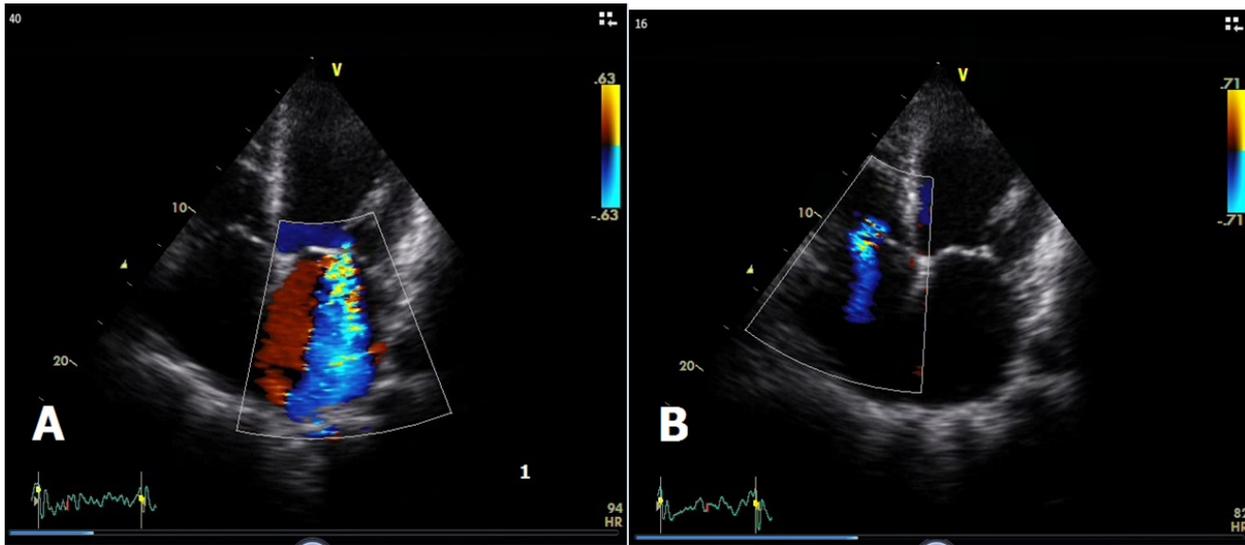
Transthoracic echocardiogram showing dilated chambers, severe mitral regurgitation (A) and mild tricuspid incompetence (B).
